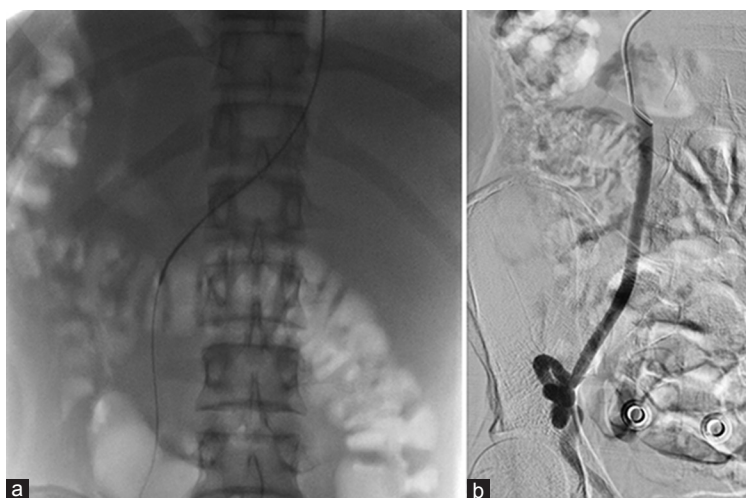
(a) Abdominal radiograph showing a catheter and wire engaged into the right renal vein and the variant course of the right internal spermatic vein. (b) Digital subtraction venography showing prominent tortuous right internal spermatic vein before embolization
